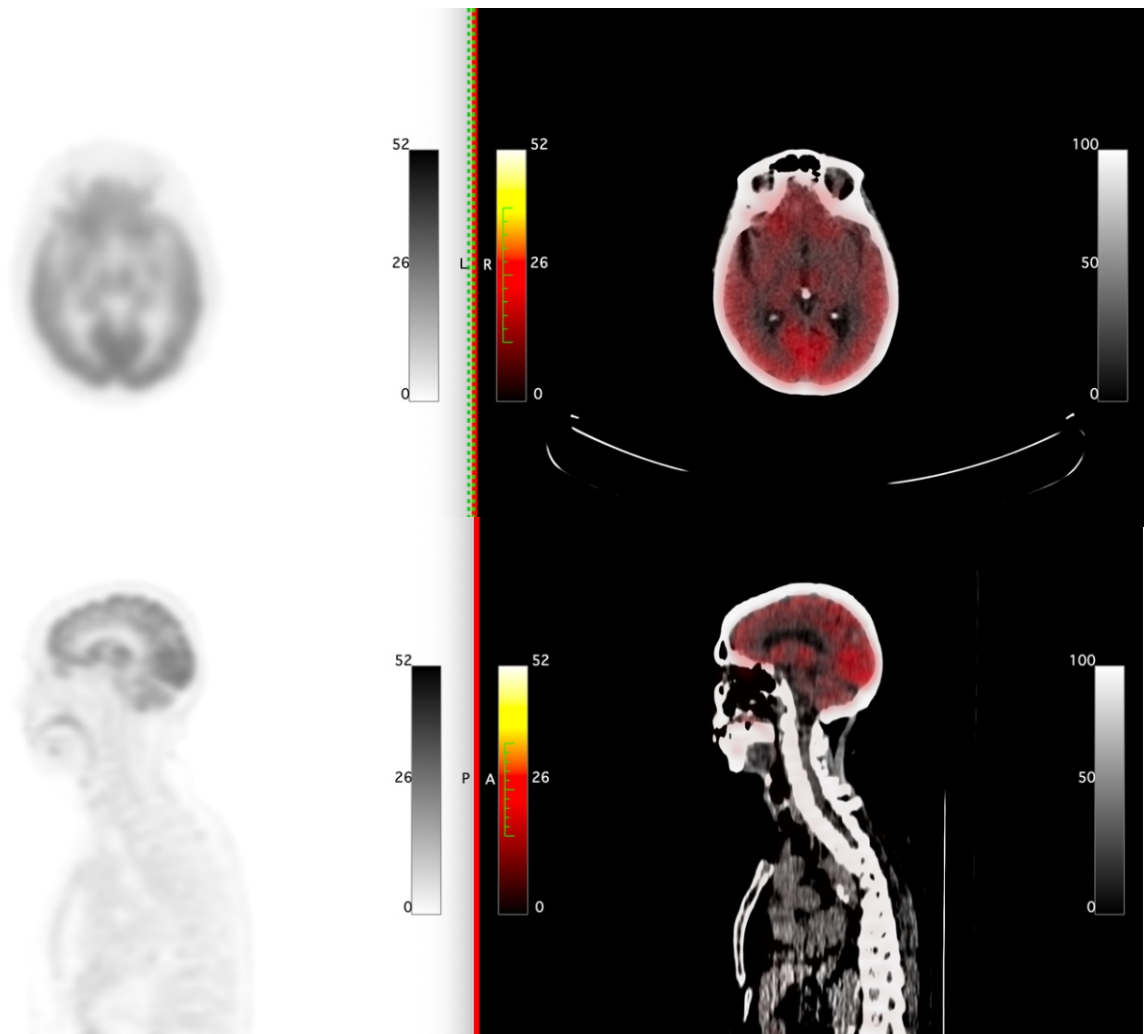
Baseline ^{18}F -FDG PET (Panel A,C) and fused PET/CT (Panel B,D) imaging scans reveal marked hypermetabolism in the region surrounding the metastatic lesion.
